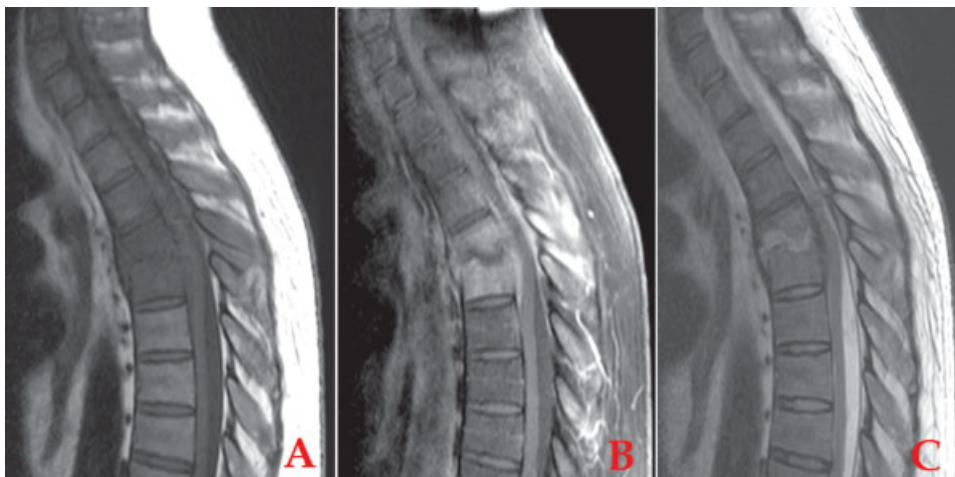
Magnetic resonance imaging scan after symptoms worsened showing an increase in the size of the lesion, inferior T5 and superior T6 end plate fractures, and local kyphosis resulting in greater spinal cord compression.
